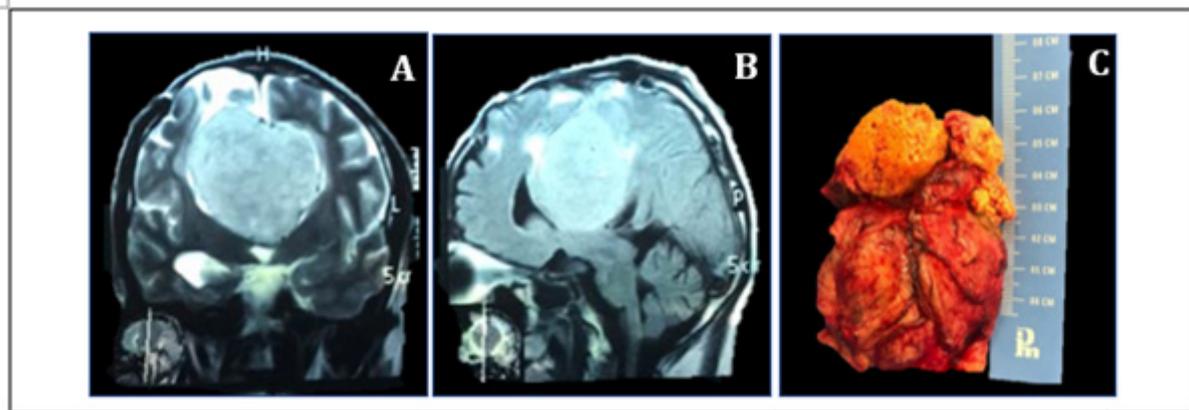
MRI(A) T2 sequence in coronal section shows axial hyperintense injury giant tumor implantation in the lower third of the falx displacement of pericalous arteries and cleavage plane. (B) Flair sequence in sagittal section, shows a tumor injury dependent of the falx of the middle third with displacement of adjacent structures and perilesional edema (C) Multilobular tumor of hard consistency, measuring 8cm x 5cm.
